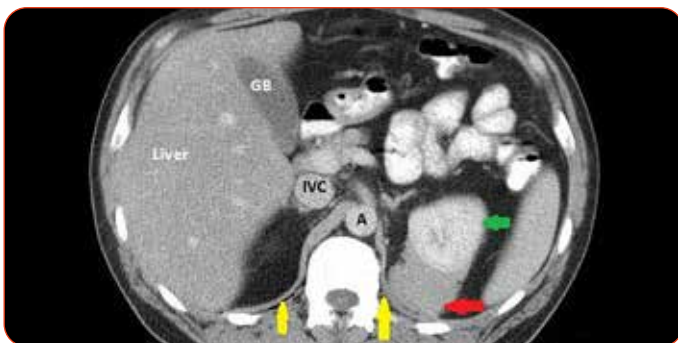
Enhanced axial CT scan showing mass (red arrow) posterior to the left kidney (green arrow) in keeping with collection of perinephric lymphomatous tissue. Crus of diaphragm (yellow arrows). GB = gallbladder. IVC = inferior vena cava. A = aorta. (Courtesy of Professor D Kim University of Wisconsin).
